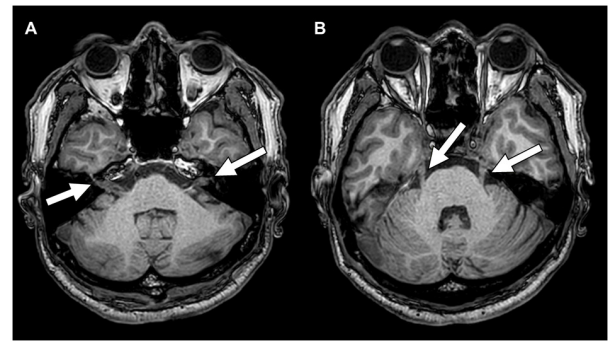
Head contrast-enhanced MRI. (A) Bilateral auditory nerve roots (VIII) and (B) bilateral trigeminal nerve roots (V), both of which were thickened on head contrast-enhanced MRI. The white arrows indicate the nerve roots. MRI, magnetic resonance imaging.
